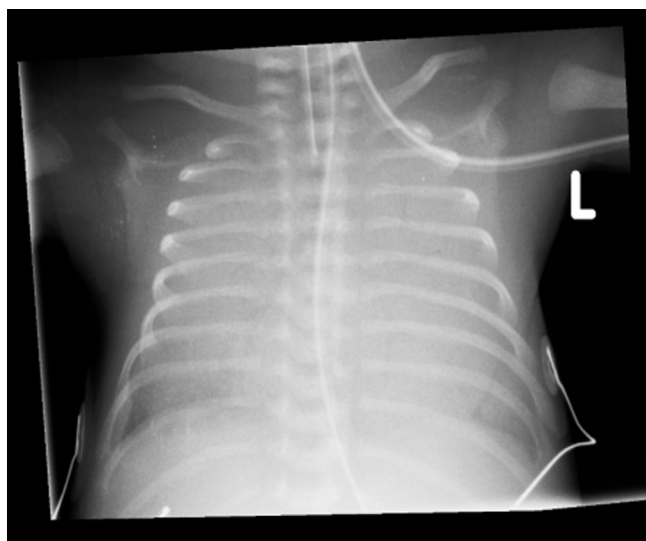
Twin #1 of first set of twins. Chest X-ray demonstrating diffuse opacifications compatible with extensive pulmonary hemorrhage.
